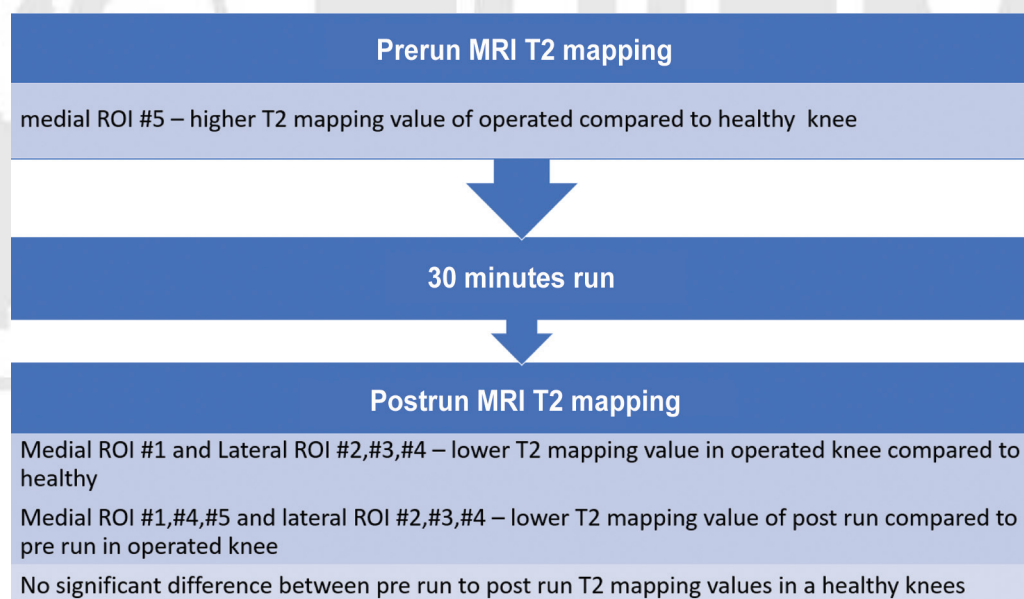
Results—summary. MRI, magnetic resonance imaging; ROI, region of interest.
